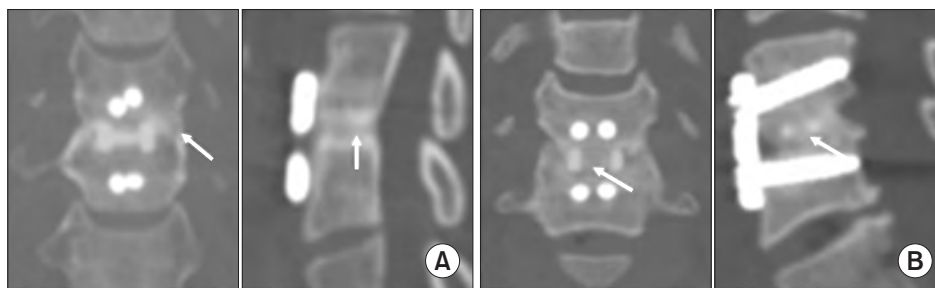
Extra-graft bone bridging (ExGBB) and intra-graft bone bridging (InGBB) in the multi-axial computed tomography scans obtained postoperatively. (A) ExGBB was defined as any bridging bone outside the graft or cage without a transverse lucent line crossing the peripheral margins of the operated disc space (arrows). (B) InGBB was defined as any cortical or trabecular bridging bone without a transverse, lucent line within the confines of the graft or cage and that was not outside the graft or cage (arrows).
